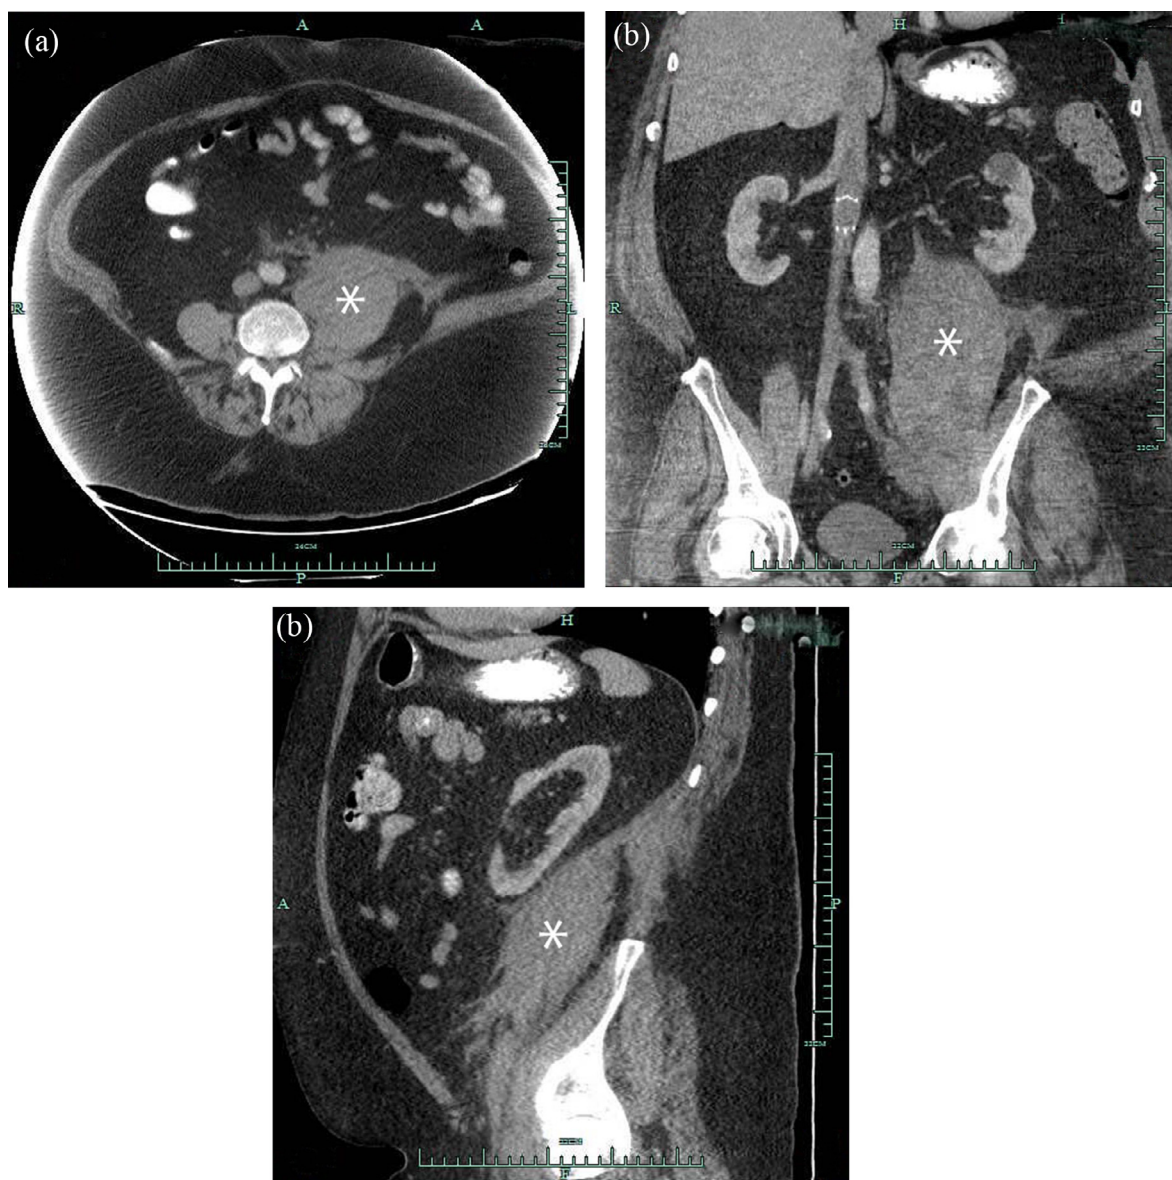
(a) Coronal abdominal CT showing a large left retroperitoneal (psoas) hematoma (*). (b) Sagittal abdominal CT showing a large left retroperitoneal (psoas) hematoma (*). (c) Axial abdominal CT showing a large left retroperitoneal (psoas) hematoma (*).
